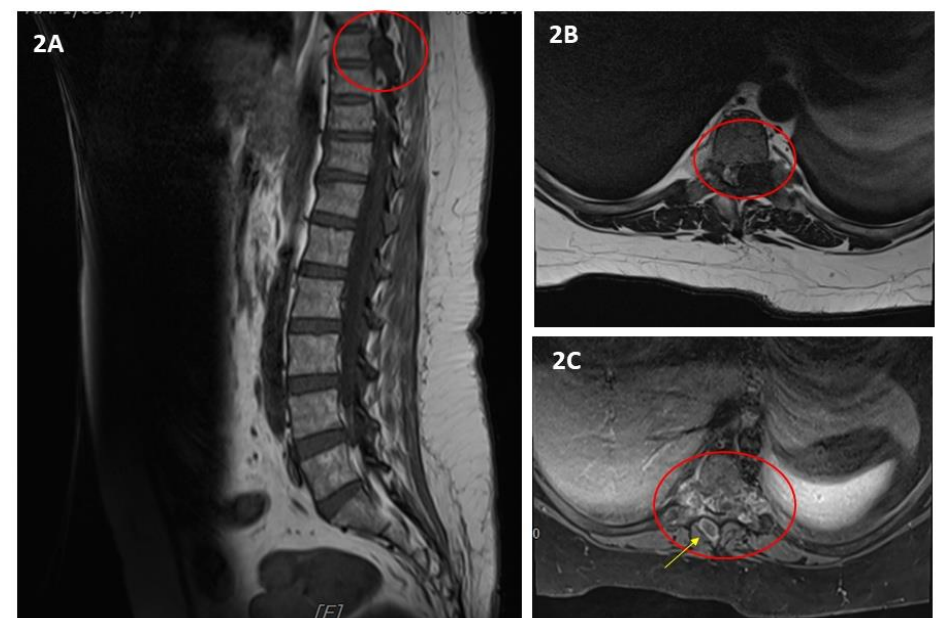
A few representative images of the contrasted whole spine MRI. T2WI axial MRI at T8 vertebral levels shows low signal tophi at bilateral pedicles, particularly on the left side causing severe spinal stenosis and cord compression (2A). The tophus shows similar low signal on T1WI which is shown on sagittal MRI (2B) and following contrast administration, it shows heterogeneous enhancement with a small rim enhancing collection seen in the right multifidus muscle posteriorly (2C). Bilateral exiting nerve roots are not appreciated, likely to be compressed.
